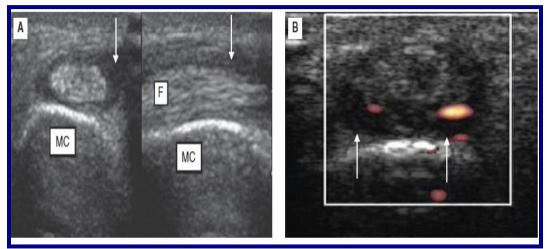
A Transverse and longitudinal image on flexor aspect of MCP joint showing hypoechoic synovial thickening (white arrows) surrounding the echogenic flexor tendon (F) to second digit consistent with tenosynovitis. MC = metacarpal (image-A). B Transverse image showing increased vascularity on power Doppler. (6)
